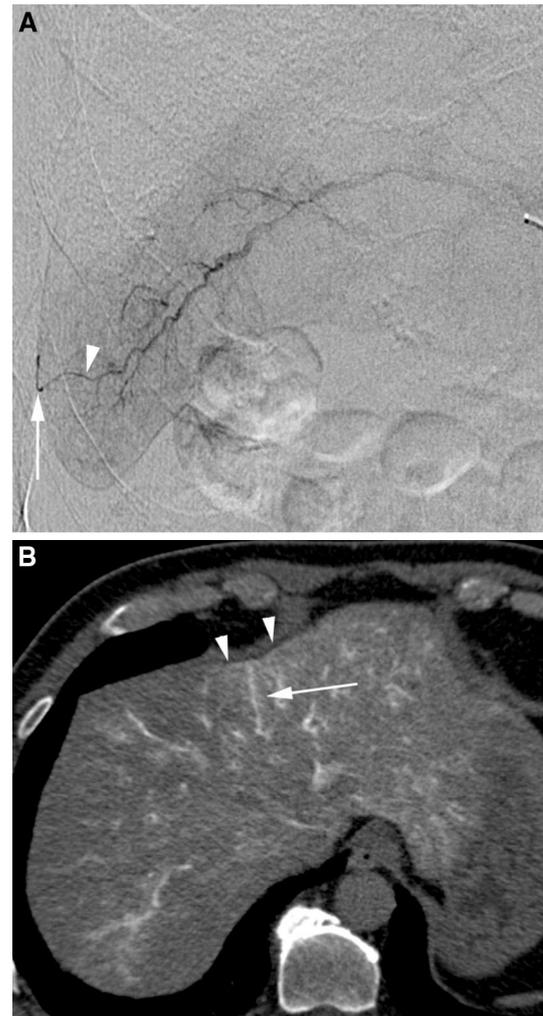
The isolated arteries demonstrated on angiography and CT during hepatic angiography. a Angiography. The selective angiography of the posterior inferior branch of the right hepatic artery shows the isolated artery (arrowhead), capsular branch of the intra-hepatic artery, and capsular artery (arrow) on the surface of the liver. b CT during hepatic angiography. The proper hepatic artery was selectively cannulated using a microcatheter during angiographic study. Iodine contrast (150 mgI/mL) was injected through this catheter at a rate of 1.5 mL/s for a total of 35 mL. The CT scan was started 20 s after the contrast material injection was initiated. The isolated artery (arrow) was identified in the left lobe of the liver and the enhancement of the hepatic surface (arrowheads) owing to the capsular arteries was also observed. Note that (a) and (b) are different cases
